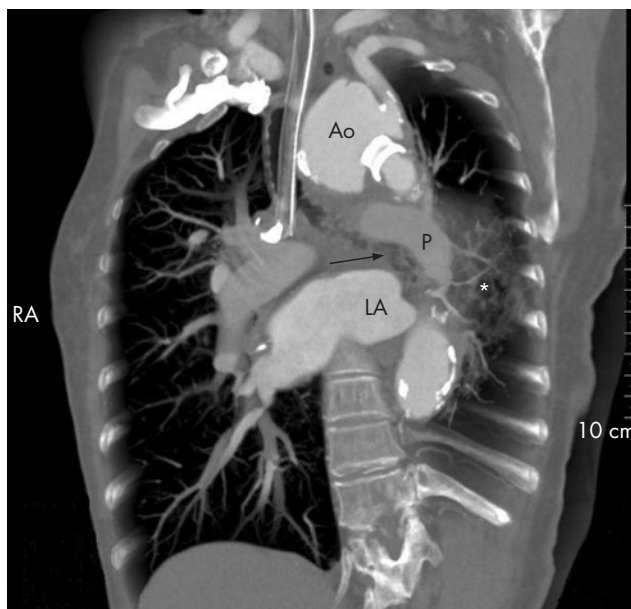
An oblique coronal maximum intensity projection reformatted image, obtained with 64 multislice computed tomography, demonstrating non-tapering distal branches of the left pulmonary artery with an adjacent area of ground-glass attenuation, and indicating the culprit lesion (asterisk: the highest attenuation was 95 HU). Arrow, left main bronchus; Ao, aortic arch; LA, left atrium; P, left pulmonary artery.
